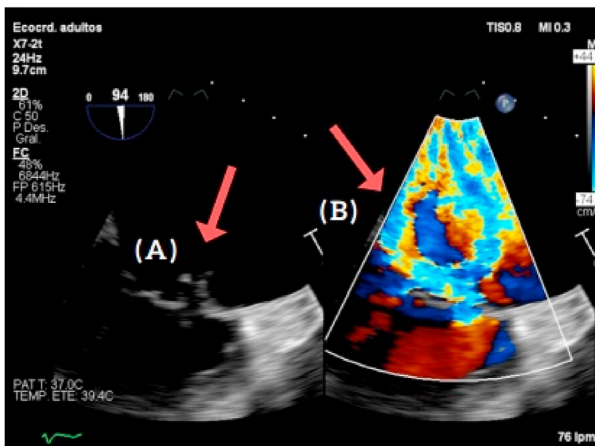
Transesophageal echocardiogram. (A) Anterior mitral valve vegetation of 10 × 8 mm. (B) Colour Doppler image showing severe mitral regurgitation.
